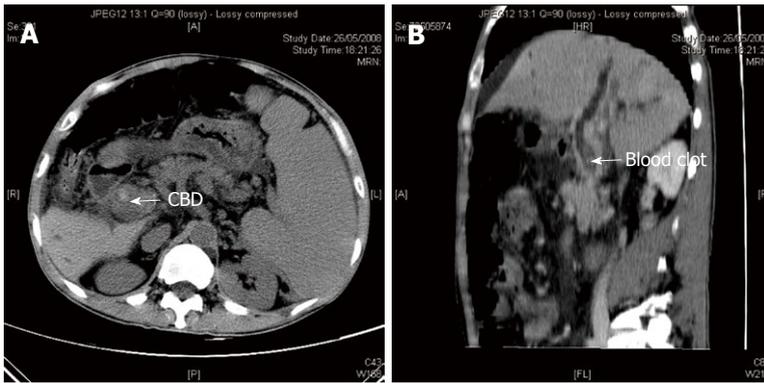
Abdominal computer tomography. A: Non-contrast CT scan showing a hyperdense lesion inside the common bile duct causing upstream biliary dilatation; B: Contrast enhanced CT scan (sagittal view) showed a non-enhanced lesion inside the common bile duct.
